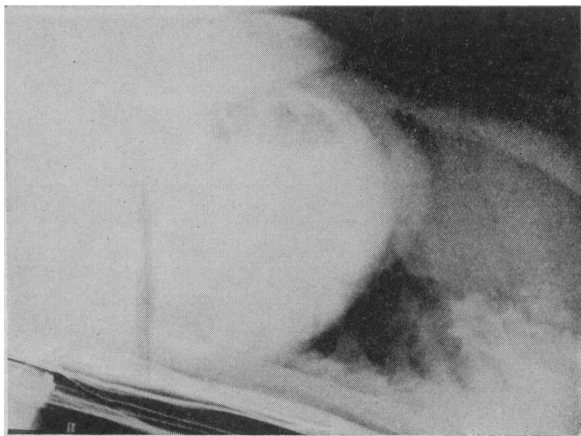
Roentgenogram, showing crowding of heart and lungs in extreme lithotomy position.
